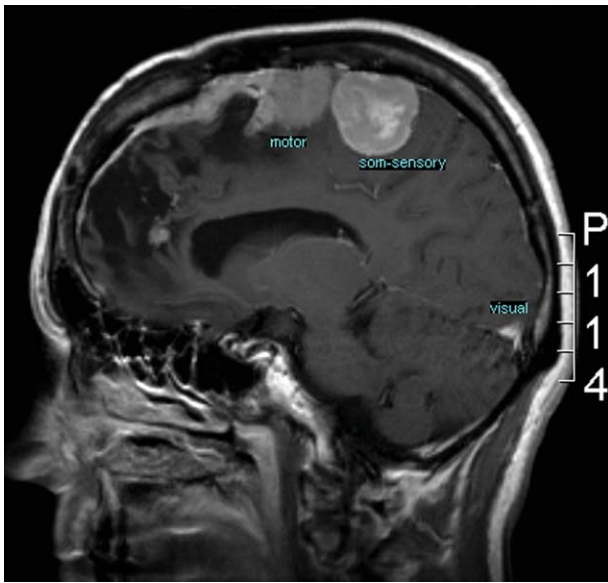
This is a T1-weighted magnetic resonance image (sagittal view) with gadolinium contrast from Patient 4, who had severe cognitive problems after she underwent repeated neurosurgical resections and received definitive radiotherapy for a meningioma “en plaque.” Som-sensory indicates somatosensory.
